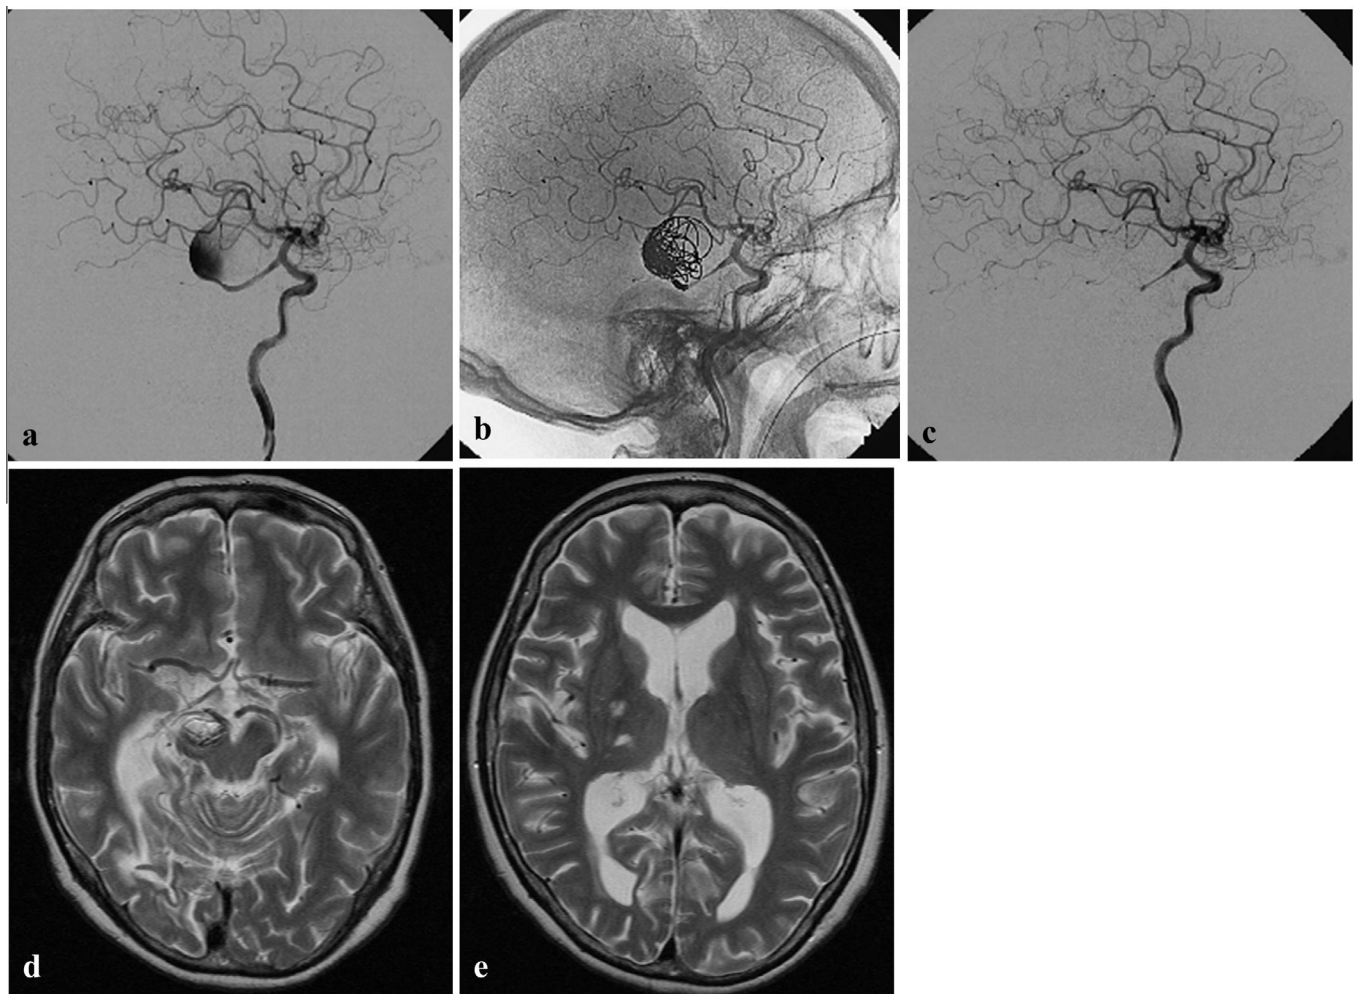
Patient 5. Lateral internal carotid artery angiogram (a) before and (b, c) after endovascular therapy. A large aneurysm with a fetal-type posterior cerebral artery (PCA) is shown. Several coils were inserted into the aneurysm to occlude the parent artery. (d, e) An axial T2-weighted MRI after parent artery occlusion shows a cerebral infarction in the right PCA territory and right thalamus.
